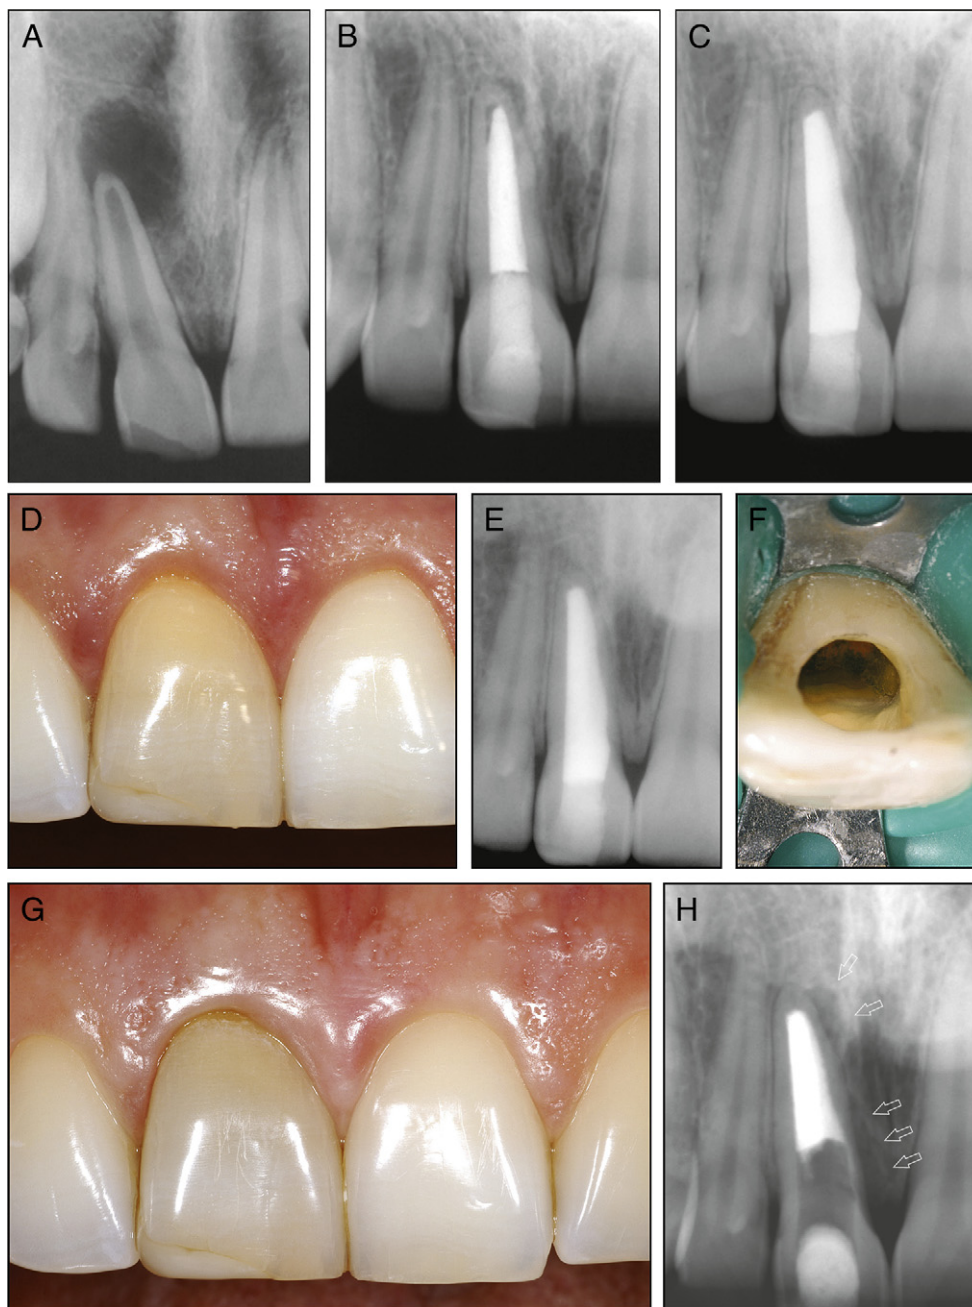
(A) Large periapical radiolucency associated with tooth #8. (B) Four-year follow-up radiograph. The radiolucency had considerably reduced in size, but healing was not observed. A radiolucent area is now visible apical to the root canal filling. This was not present in the postoperative radiograph and is attributable to dissolution and washing out of calcium hydroxide incompletely removed from the root canal before obturation. (C) Radiograph taken 2 years and 4 months after retreatment. Complete healing was evident. (D) Eleven years and 7 months after retreatment the tooth had suddenly turned yellowish. (E) No radiographic changes could be seen at this time. (F) Removal of restorative materials disclosed a fracture line on the mesial wall of the pulp chamber. (G) The crown was successfully bleached, but the patient returned only after 5 years and 9 months. The tooth had a grayish color. (H) The radiograph taken at this time revealed an emerging radiolucency on the mesial aspect of the apex and an angular defect in the marginal periodontal bone (arrows).
